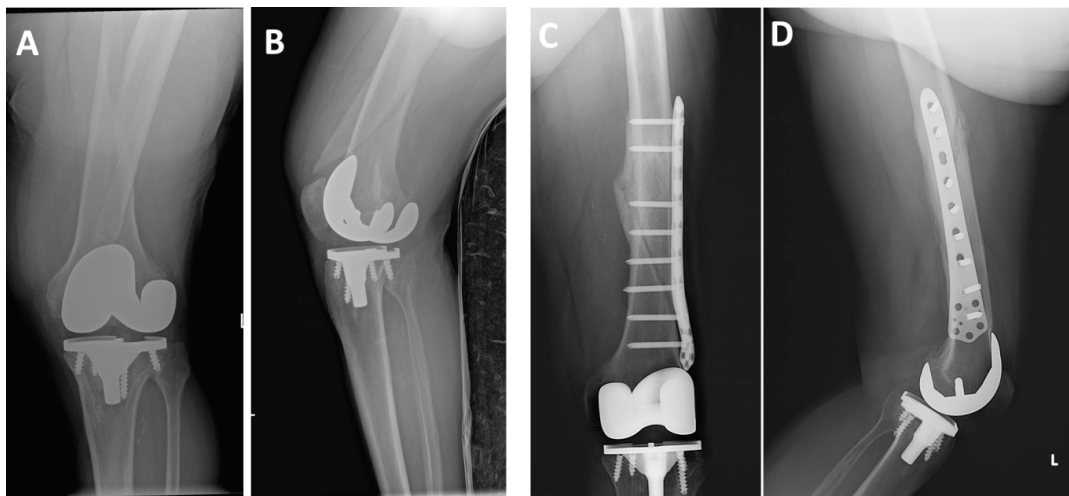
Radiographic images of a patient who suffered a periprosthetic fracture of the left femur 4 years after cementless TKA. A, B – Anteroposterior and laterolateral image of fractured femur; C, D – Postoperative anteroposterior and laterolateral images of left femur 8 months after osteosynthesis.
